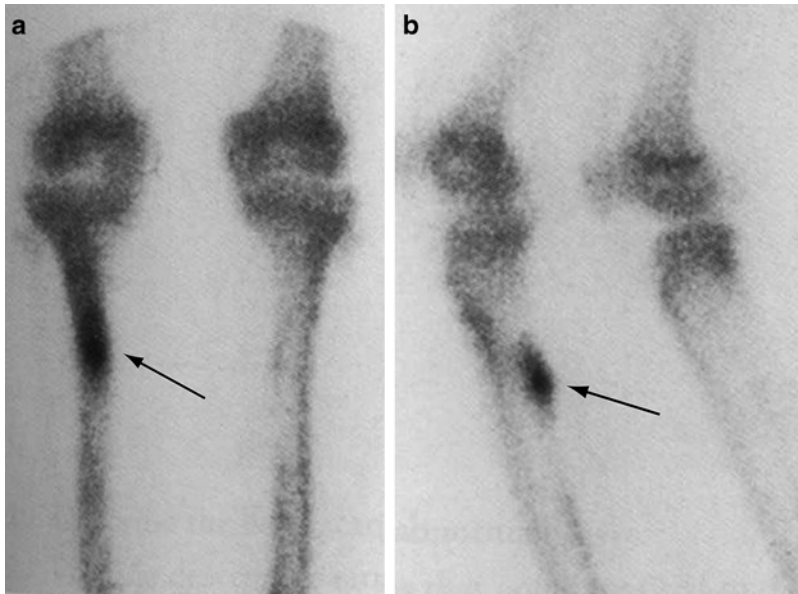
Typical scintigraphic findings of a stress fracture. Delayed static images of the tibia from a whole body bone scan utilizing Tc-99m-MDP in the frontal (a) and oblique (b) projections show a characteristic appearance
